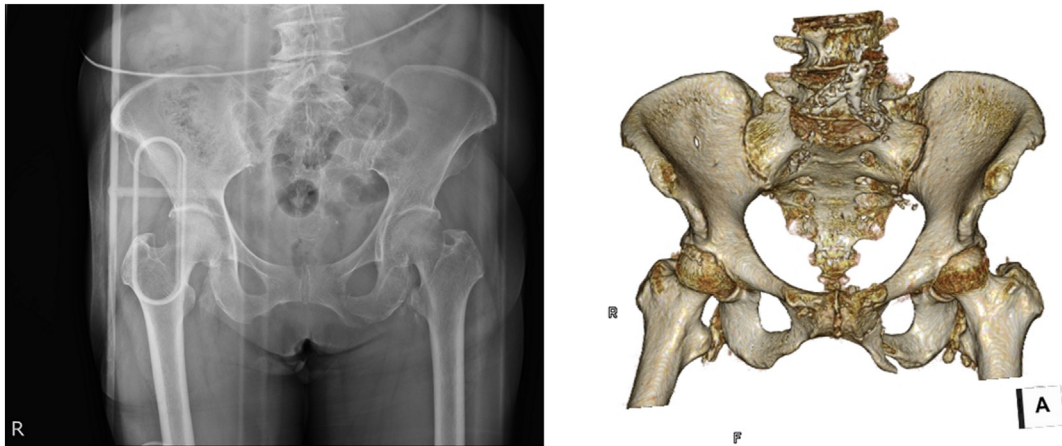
Radiograph and 3D-computed tomography (CT) scan showing a stable pelvic fracture.
